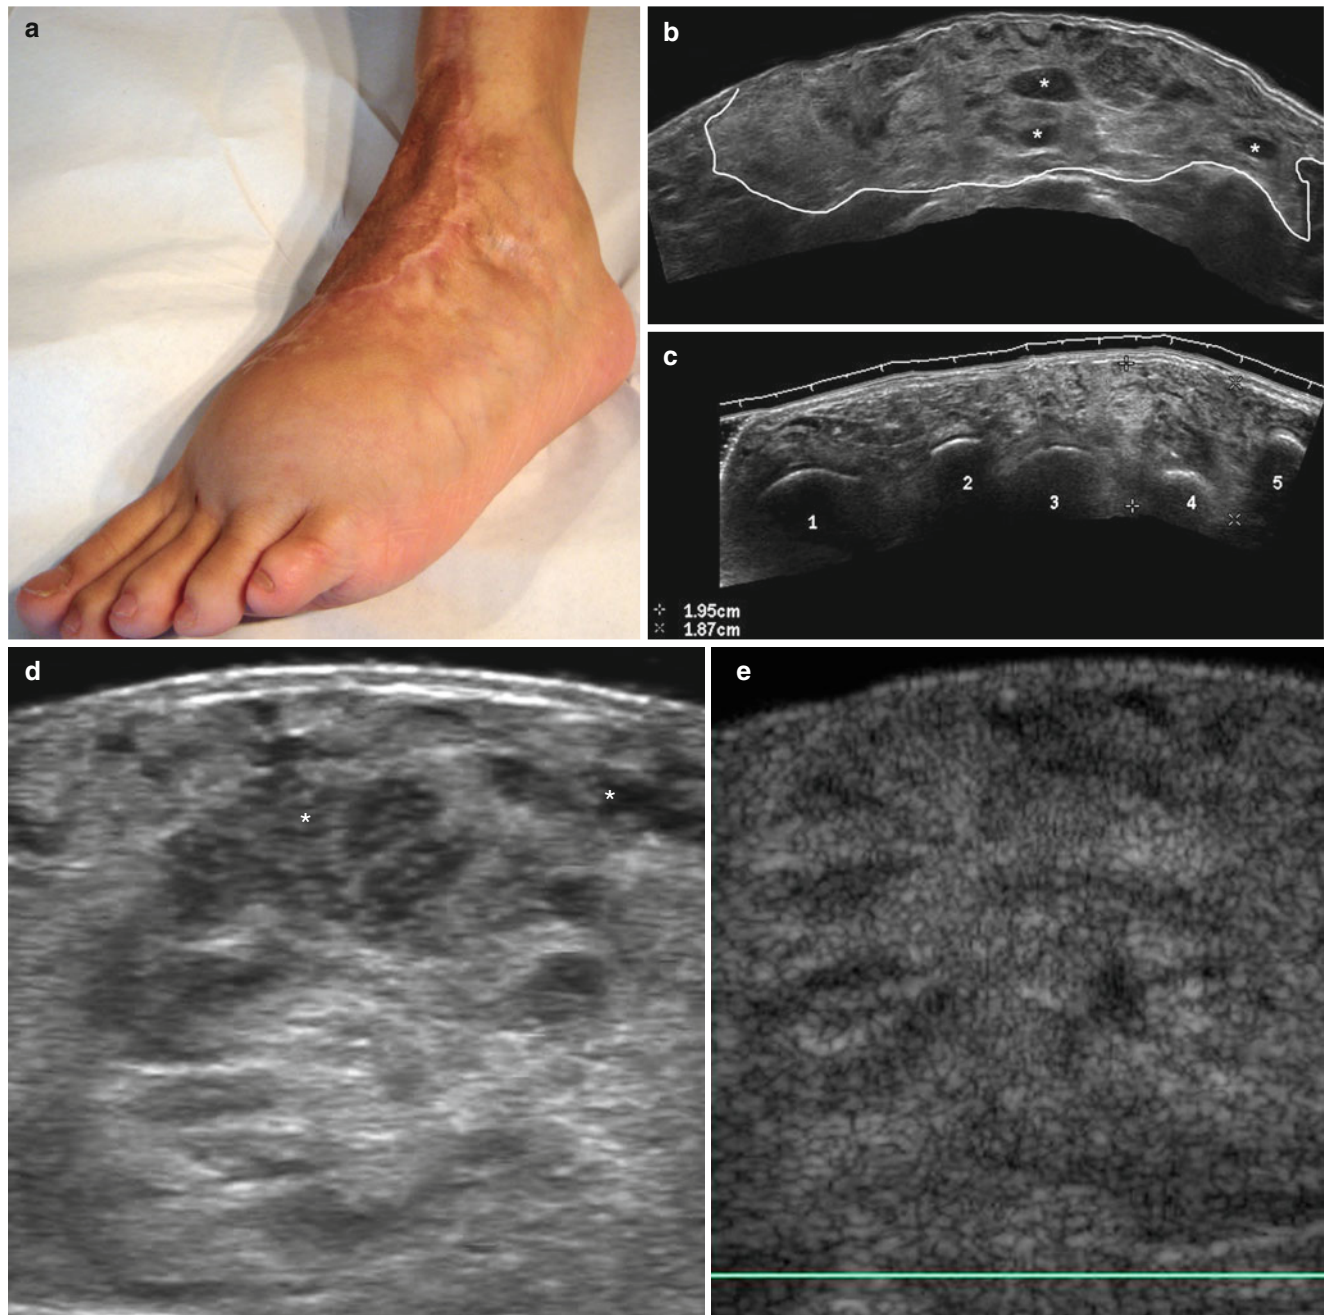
(a–g) Recurrent angiomyxoma. (a) Clinical image shows swelling in the dorsum of the left foot. The patient was operated on 1 year previously (scar) and the biopsy was positive for angiomyxoma. (b–d) Grey scale ultrasound (transverse axis; b, ankle level; c, foot-metatarsal level (numbers); d, zoom dorsum of the foot level) demonstrates ill-defined heterogeneous structure with some oval-shaped
